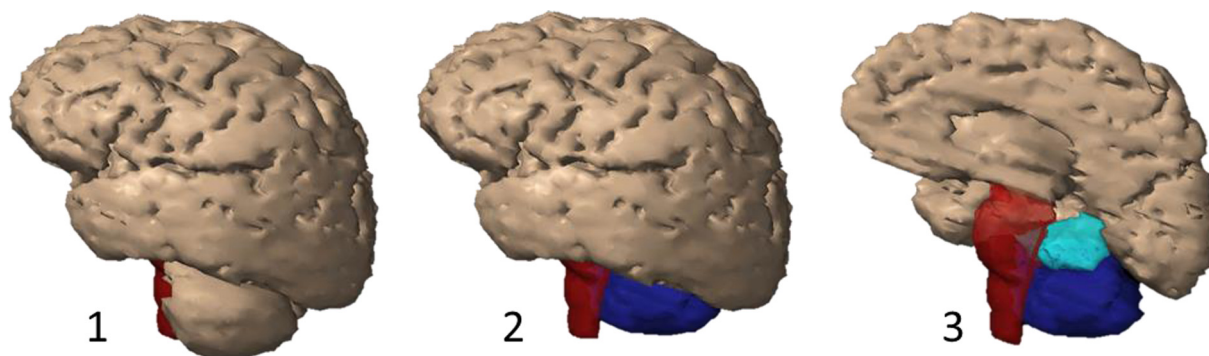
3D view of the Brain, brainstem, cerebellum posterior and anterior. Lateral view of a 3D-reconstruction on CT of: 1. Total brain (brown) and brainstem (red). 2. Brain (brown), brainstem (red), cerebellum posterior* (dark blue). 3. Right brain (brown), brainstem (red), right cerebellum anterior* (light blue) and right cerebellum posterior* (dark blue). *In accordance to Atlas for Neuro-Oncology (Eekers et al., submitted). (For interpretation of the references to colour in this figure legend, the reader is referred to the web version of this article.)
